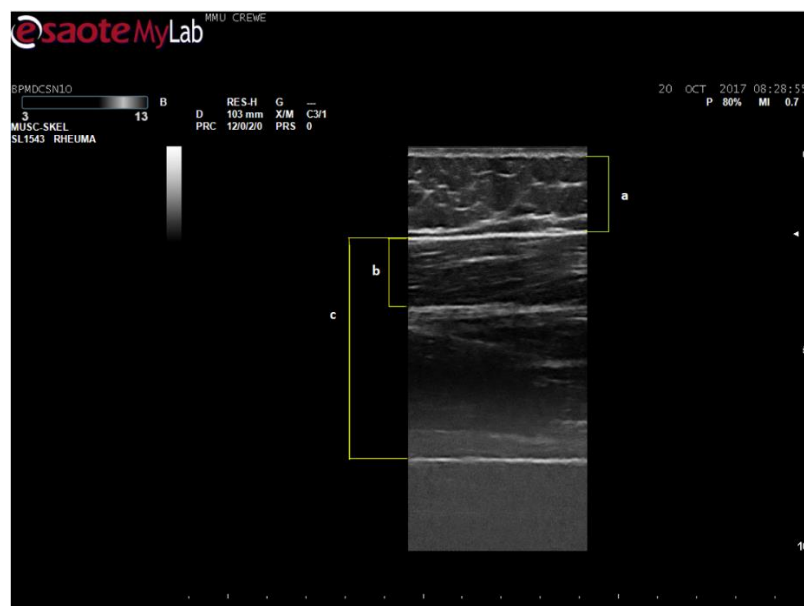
Ultrasound image a) Fat thickness b) Semitendinosus thickness c) Lean total thickness. Note: image recorded during tests of the current thesis.
